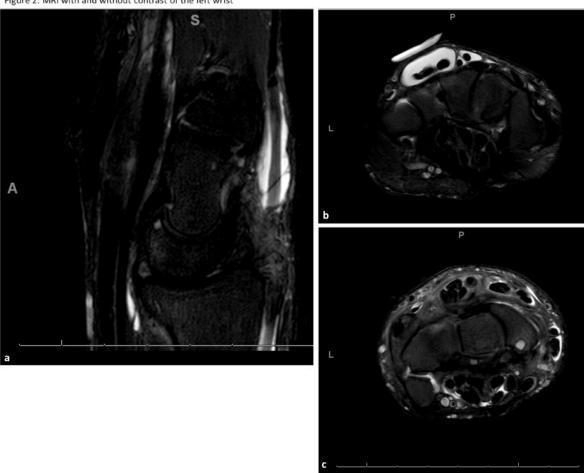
MRI with and without contrast of the left wrist demonstrating tenosynovitis, most severely affecting the extensor digitorum longus tendons on sagittal view (hyperintensity seen in panel a) but also impacting flexor digitorum longus and flexor pollicis longus tendons as demonstrated by the circumferential fluid within the tendon sheaths on axial view (panel b). Rounded foci of hyperintense signal on the fluid sensitive sequence (panel c) within the distal radius, scaphoid, and lunate likely reflect bony cysts. This is fluid around the radioulnar and ulnotriquetral recess which does not enhance and is consistent with amyloid deposition.
